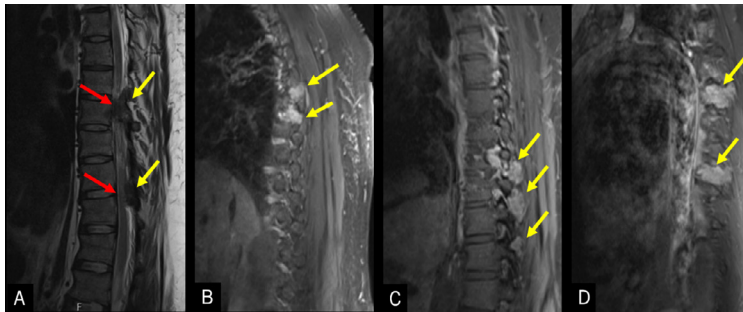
Sagittal T2 (A) and postcontrast sagittal T1 (B-D) MRI images of the thoracic spine again show the multifocal T2 hypointense, enhancing masses involving the adjacent vertebral bodies and posterior elements (yellow arrows). Some of these masses extend into the epidural space causing thecal sac narrowing and spinal cord compression at T7-8 and T10-11 levels (red arrows).
